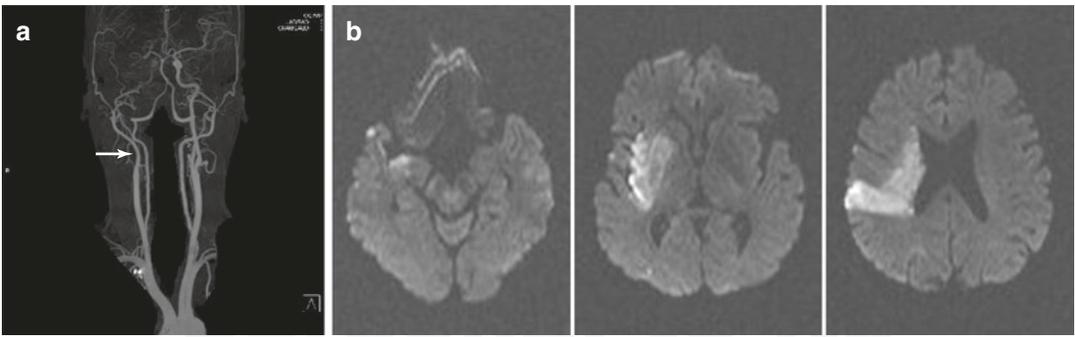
In situ thrombosis, internal carotid artery (ICA). (a) Occlusion of right proximal ICA with faintly visible right distal ICA on CT angiography. (b) Acute infarct of insular, basal ganglia, and some frontotemporal cortex on diffusion-weighted image
